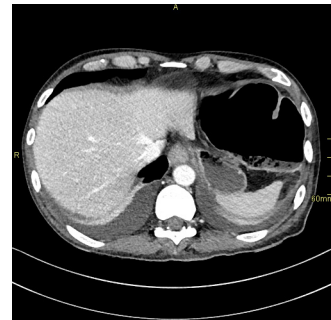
A CT image of the dilated transverse colon.
